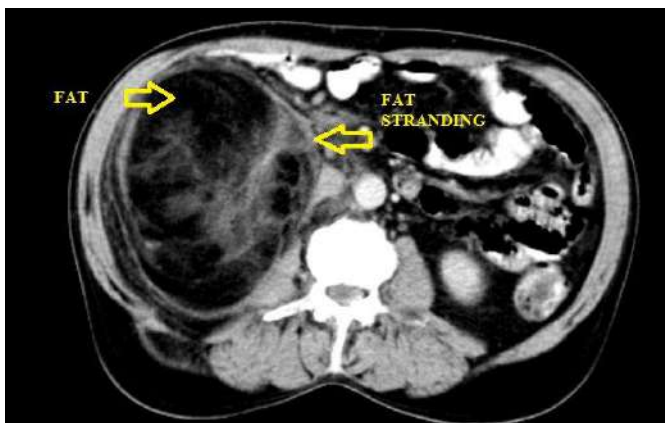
CT image showing fatty replacement of right kidney
